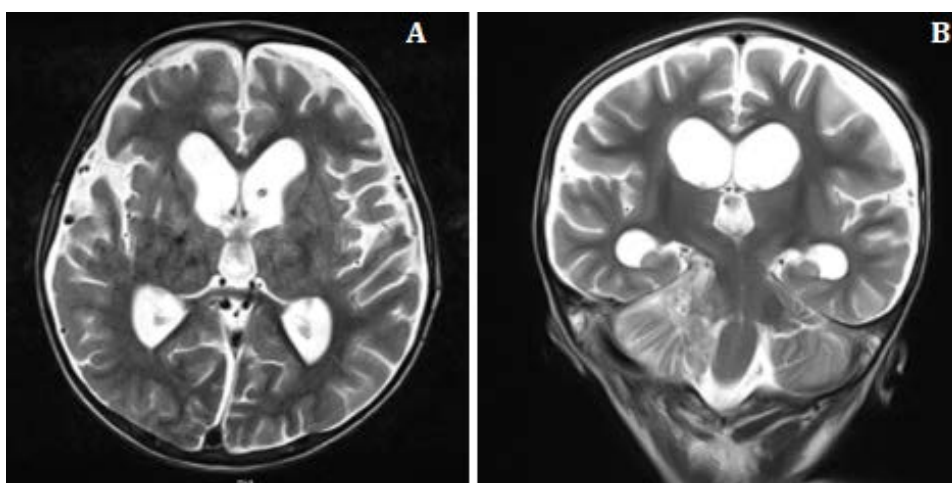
2-year-old male with medulloblastoma. FINDINGS: Post-surgical contrast-enhanced brain MRI axial (A) and coronal (B) that shows changes consistent with a right occipital craniectomy with an area of encephalomalacia and gliosis at the lower margin of the right cerebellar hemisphere; a lesion with extra-axial characteristics occupying the prepontine, right pontocerebellar, and bulbar cisterns, which is hypointense on T1, heterogeneous on T2, and shows intense enhancement with contrast administration. It presents with an intracanalicular extension component and exerts a moderate mass effect on the middle cerebellar peduncle. Meningeal enhancement is observed supra and infratentorially. Extra-axial collections with fluid signal in subdural morphology are seen in the frontoparietal convexities, without apparent compressive effect. The ventricular system is moderately enlarged in the midline; there are no signs of transependymal migration of cerebrospinal fluid. TECHNIQUE: Study with T1, T2, diffusion, and FLAIR sequences, as well as contrast-enhanced T1 sequences in various plane. Source: Patient’s medical chart, 2023.
